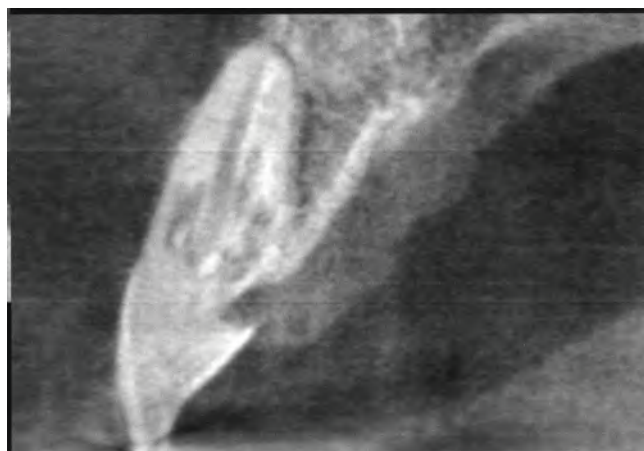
Details of alterations in root integrity that can be provided using a CBCT image, the full impact of which may not be evident on periapical radiographs. Note the external invasive resorption along the pulpal space coupled with defect on the palatal aspect of the crown at the level of the gingulum.
